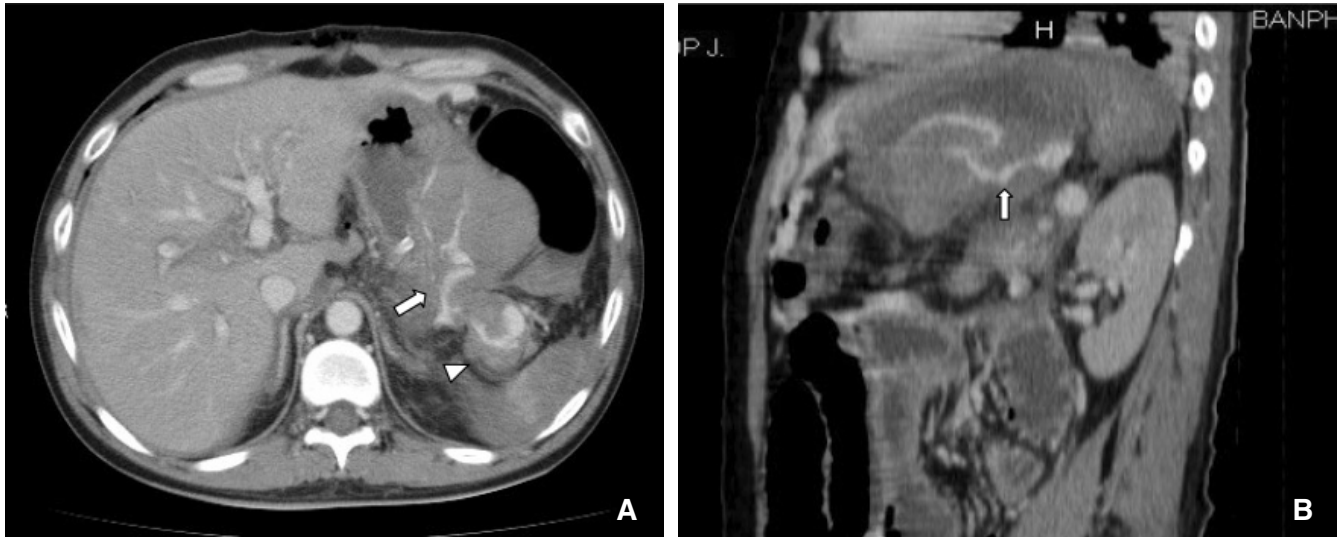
A, B, Computed tomography demonstrates abnormal dilatation of splenic artery (arrowhead) and leakage of contrast material into lesser sac (arrow).
